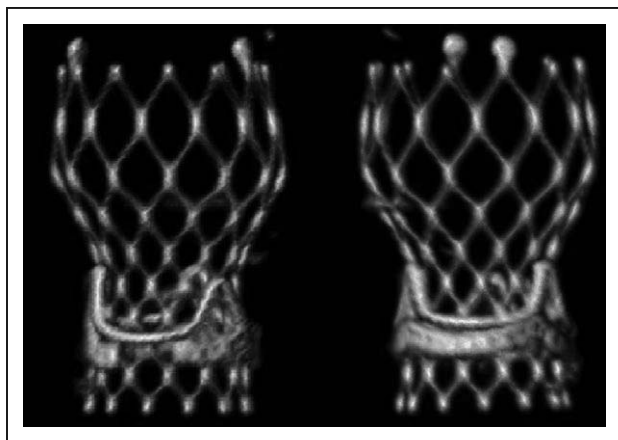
Computed tomography (CT) reconstruction of a patient who underwent valve-in-valve (VIV) transcatheter aortic valve replacement (TAVR) with a 23-mm CoreValve Evolut R in a 19-mm Edwards Magna, followed by bioprosthetic valve fracture (BVF). Left, Clear disruption of the surgical valve ring. Right, Obverse view.
